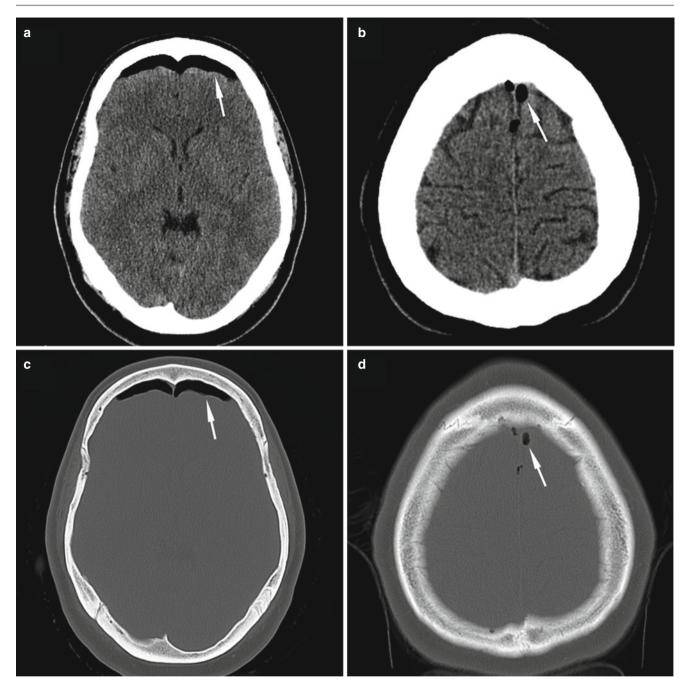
CSF leak. Noncontrast axial CT images in a patient with a postoperative CSF leak following pituitary surgery. Images (a, b) are windowed for brain soft tissue, and images (c, d) are windowed for
